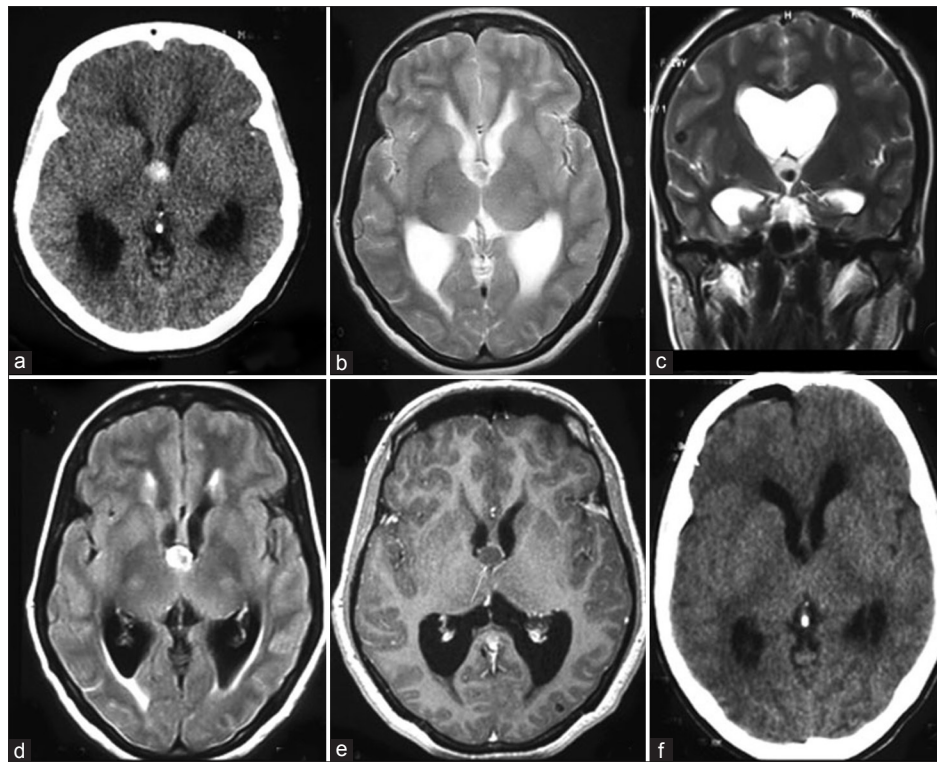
(a) Typical anterior third ventricle colloid cyst expanding the foramen of Munro and causing obstructive hydrocephalus. The preoperative axial CT (b) Shows a hyperdense cyst, appearing isointense with a central area of hypointensity on T2-weighted axial; (c) Coronal; (d) MRI. On axial FLAIR sequence; (e) The lesion is hyperintense with evidence of periventricular CSF seepage. Post-contrast axial T1-weighted MRI; (f) Demonstrates a hypointense cyst without any enhancement. This tumor was operated through a transcallosal transforaminal approach and excised completely as evidenced by the postoperative CT image
